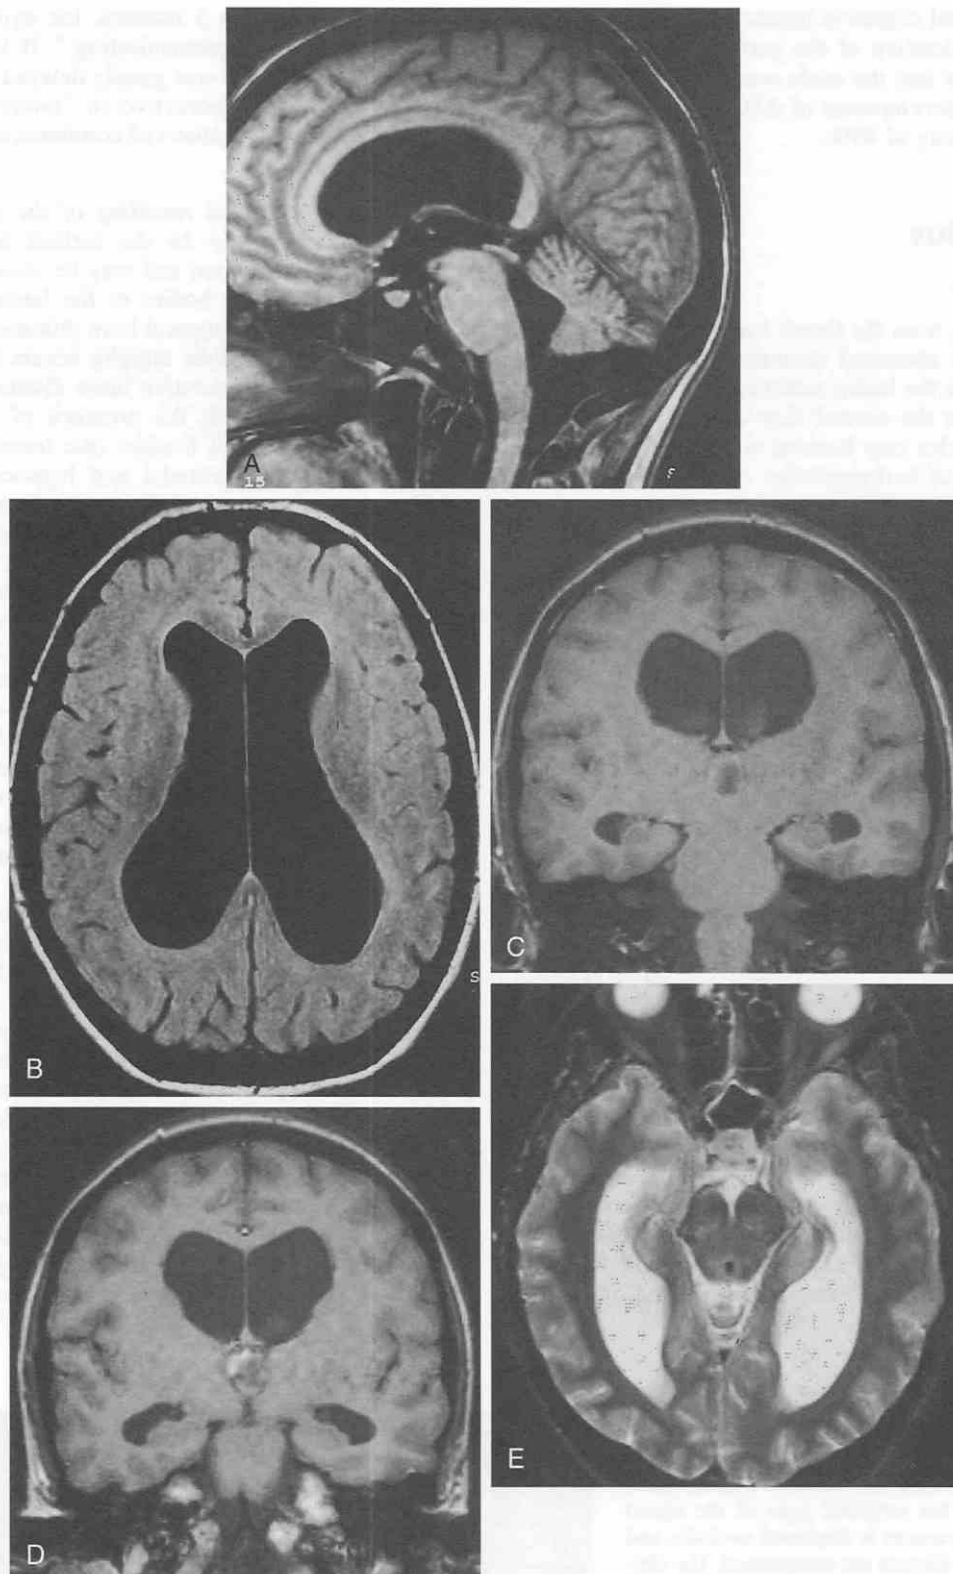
Hydrocephalus in a 47-year-old patient. *A*, Sagittal T1-weighted image demonstrates dilatation of the lateral, third, and fourth ventricles. There is bowing of the corpus callosum. *B*, Axial fluid-attenuated inversion recovery (FLAIR) image demonstrates marked dilatation of the ventricles out of proportion to the sulci. *C* and *D*, Coronal T1-weighted images demonstrate marked dilatation of the lateral ventricles, including the temporal horns. There is no hippocampal atrophy. *E*, Hydrocephalus is confirmed on this axial T2-weighted image. (From Holodny AI, George AE, Golomb J: Neurodegenerative disorders. In Edelman R, Hesselink JR (eds): Clinical Magnetic Resonance Imaging, 2nd ed. Philadelphia, WB Saunders, 1996.)
